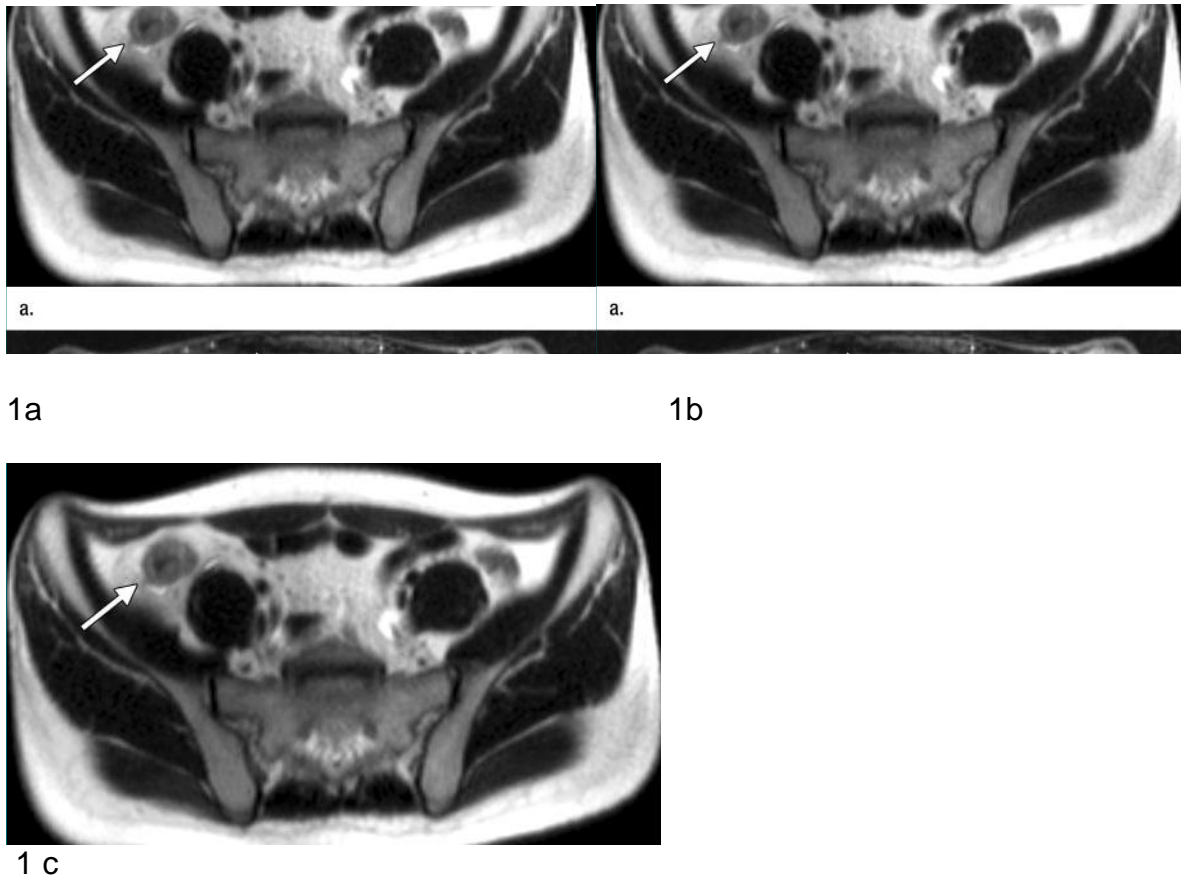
MR images in a 28-year-old man with known Crohn disease and high biologic activity (positive ESR, CRP level, and WBC count) and positive clinical indexes of activity (CDAI \square 150). (a, b) T2-weighted RARE transverse images obtained (a) without and (b) with fat suppression after oral administration of a negative contrast agent show marked diffuse wall thickening (arrow) at level of the terminal ileum, with minimal perivisceral free fluid; this can be seen better on b (arrowhead). After suppression, T2-weighted signal intensity of the wall is extremely high, suggesting diffuse wall edema and active disease. Adjacent bowel loops do not show wall or luminal abnormalities; they are clearly depicted because of low signal intensity of intestinal contrast agent. (c) Gadolinium-enhanced FLASH T1-weighted transverse MR image obtained with fat suppression show marked diffuse wall thickening and marked wall enhancement at level of the distal ileum (arrow) and dilatation of local mesenteric vessels (ie, "comb sign") (arrowheads) (31). These findings are concordant with those observed on T2-weighted images and are suggestive of active Crohn disease.
